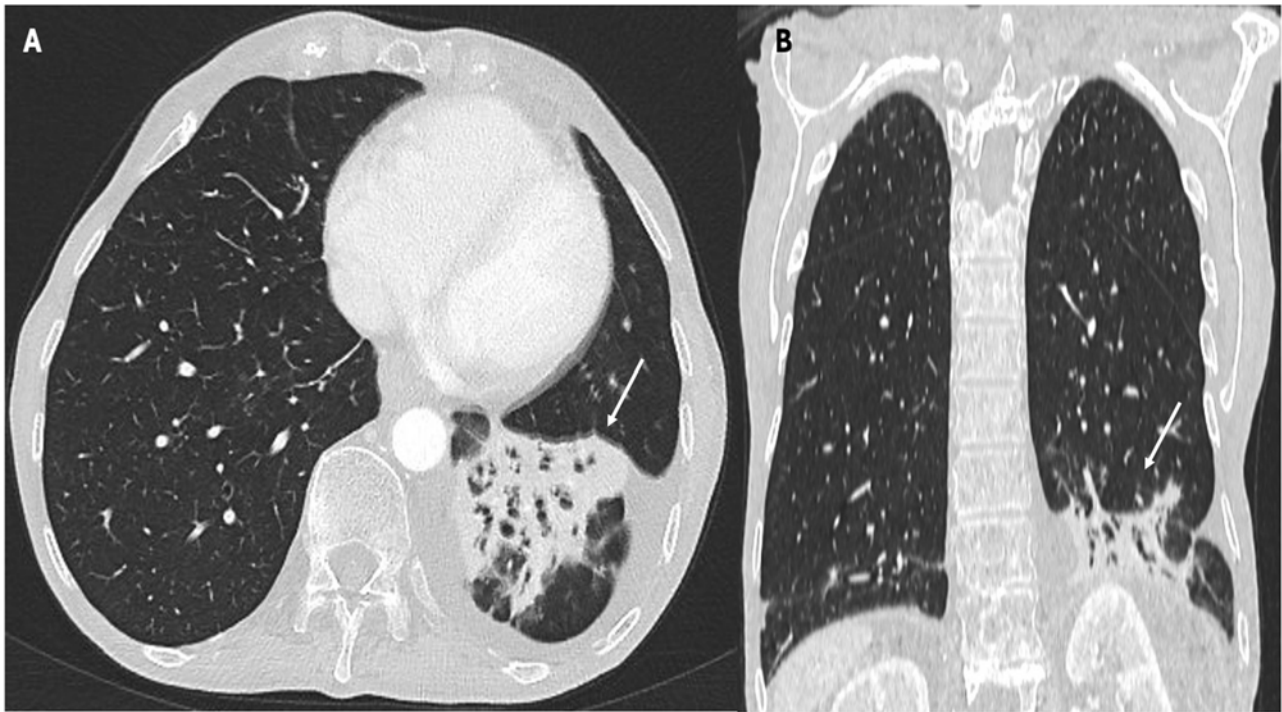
(A) Axial and (B) coronal CT scan with lung parenchyma reconstruction demonstrating consolidation in the left lower lobe characterized by air bronchograms (see arrows). The image is from a 52-year-old patient undergoing therapy with nivolumab for locally advanced gastric cancer.
